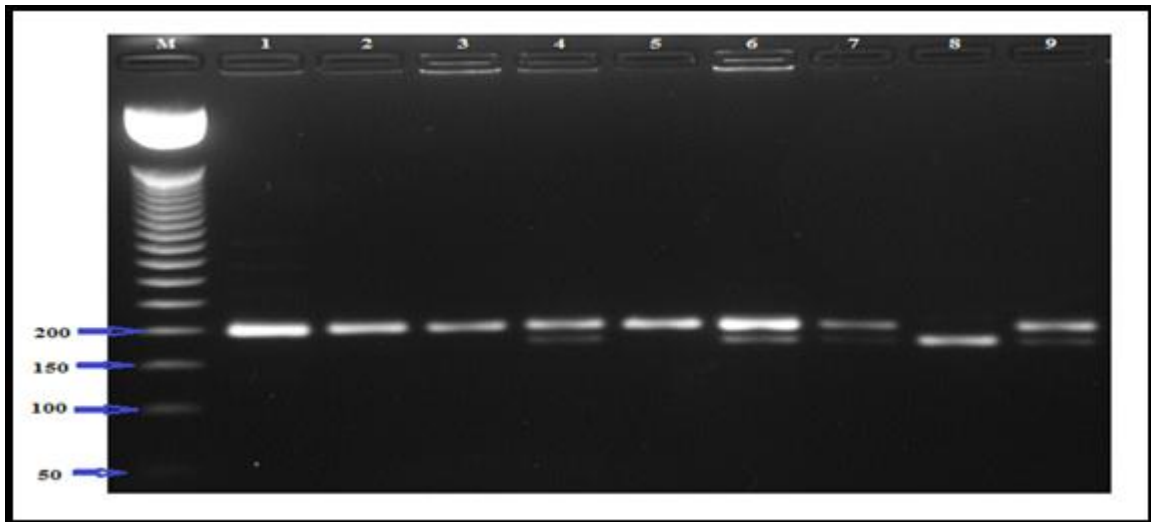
The *Hin*I restriction digested PCR product profile of MTHFR gene. Lane M: DNA Marker, Lane 1,2, 3 and 5 CC genotype, Lane 4,6,7 and 9 show CT genotype, Lane 8 shows TT genotype.
